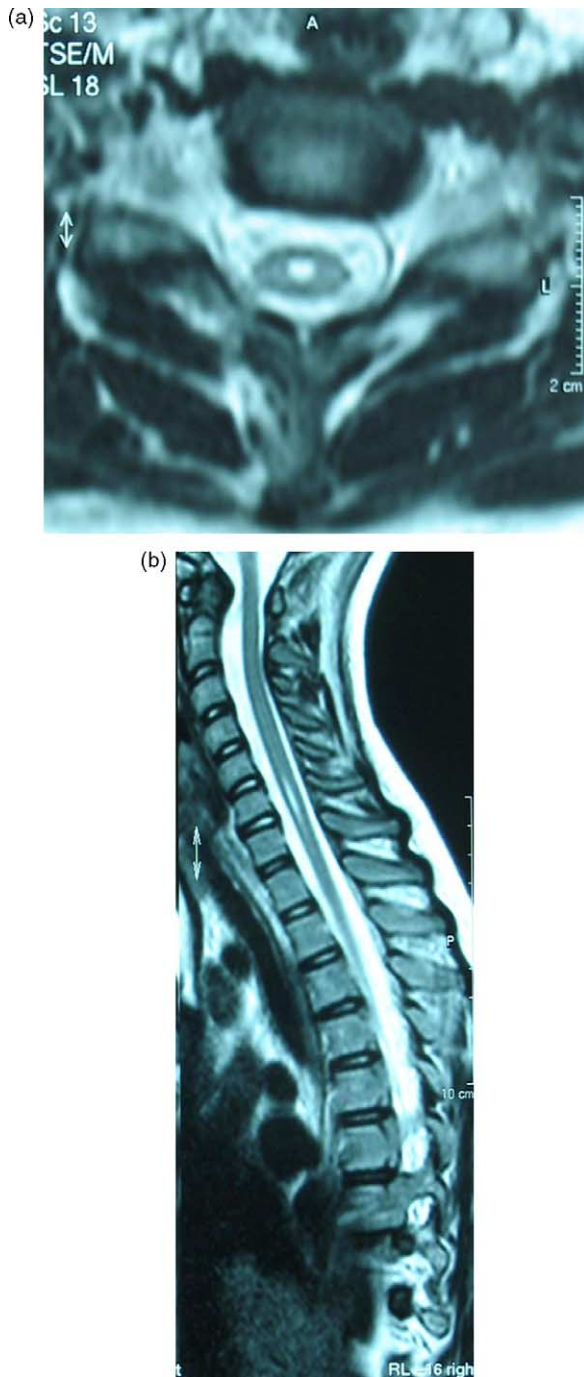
Case 1. T2-weighted axial (a) and sagittal (b) MRI scans of the spinal cord disclosing a small hydrosyringomielic cavity between the fifth and seventh cervical vertebrae.
